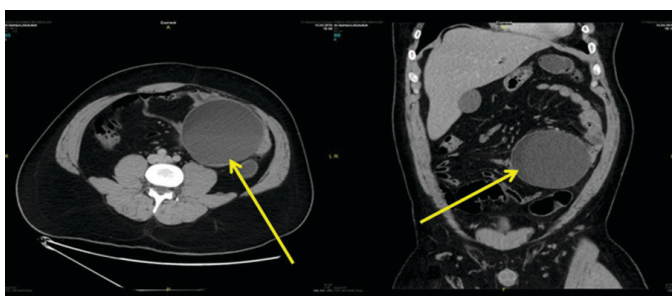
Computed tomography showing single, well defined, mesenteric cystic lesion with thin smooth enhancing wall and fat- fluid level, measuring about 10.5 cm, located in the left side of the mid-abdomen, displacing the adjacent bowel.
